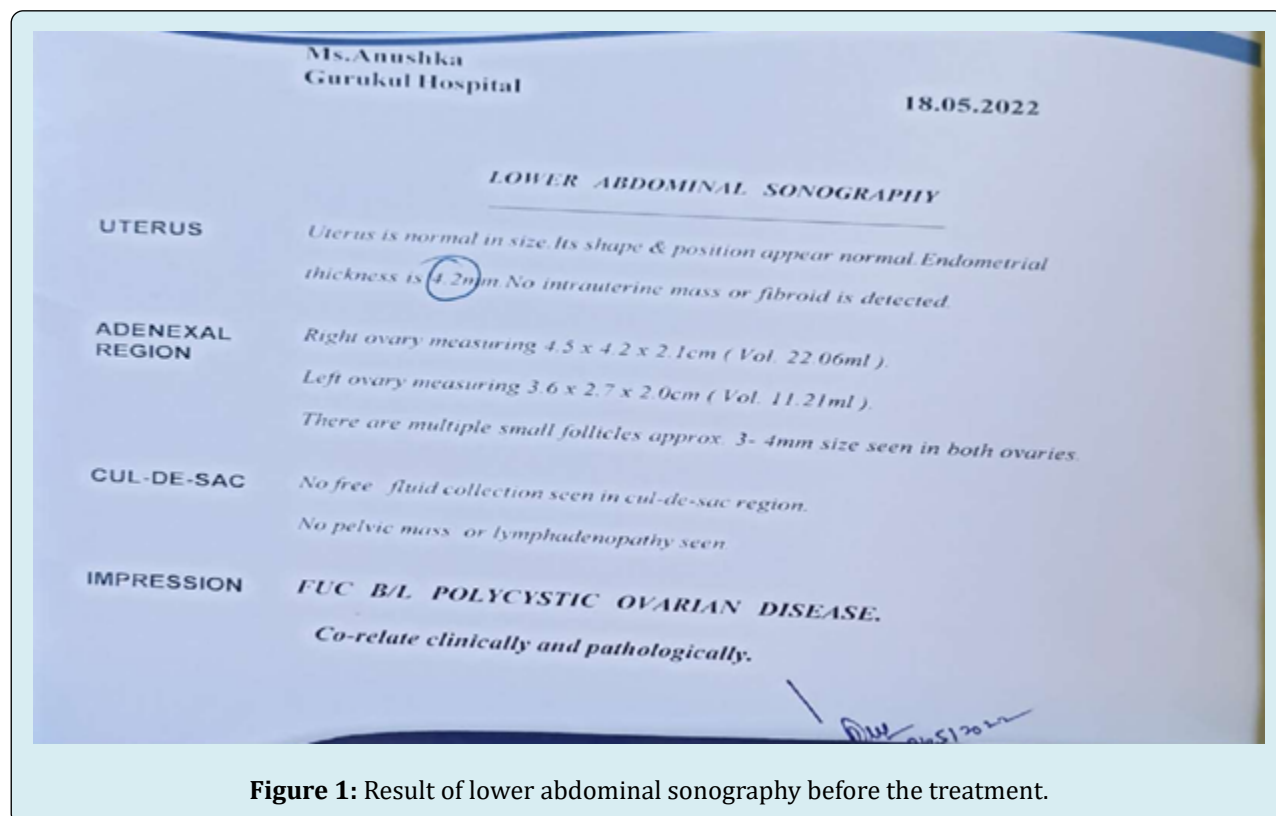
Result of lower abdominal sonography before the treatment.
